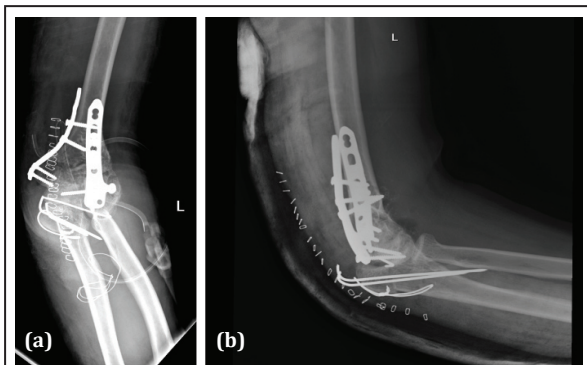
Immediate postoperative radiography of left elbow antero-posterior and lateral views.
